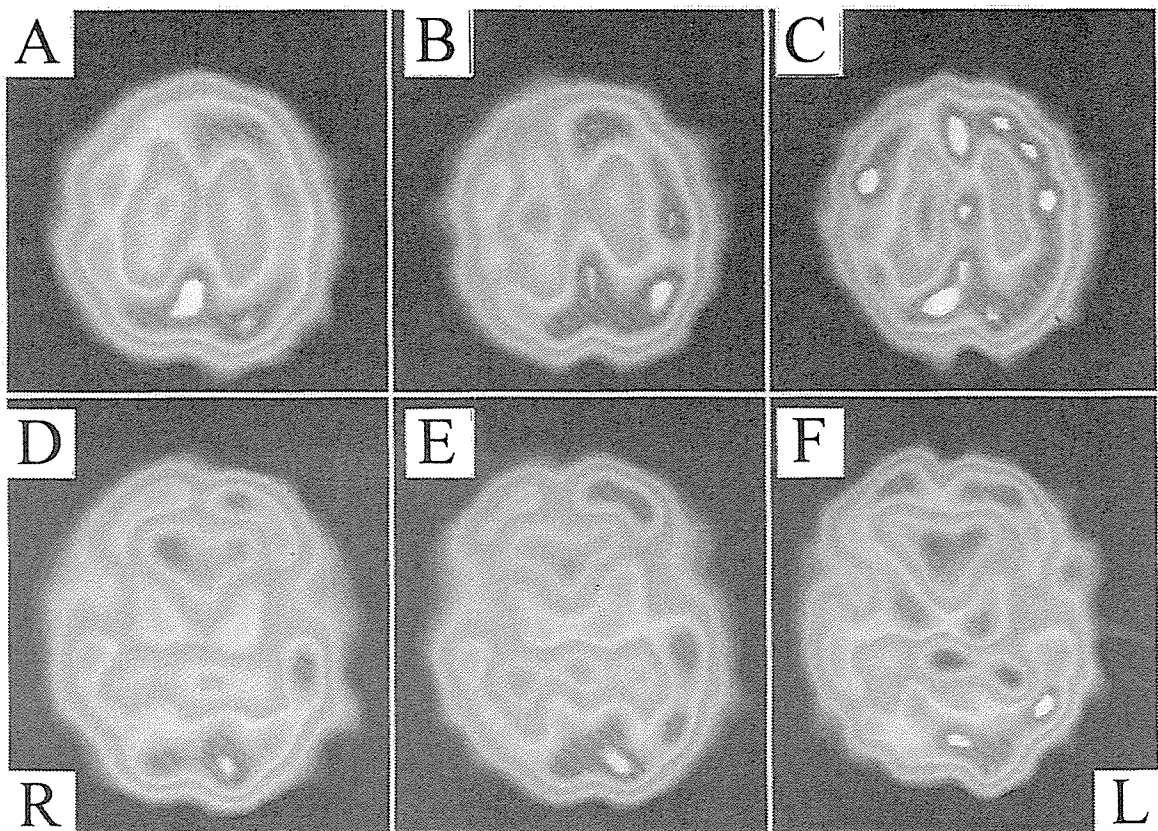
Case 1. A and D: Preoperative ¹²³I-IMP SPECT scans demonstrating severe hypoperfusion in the right hemisphere including the basal ganglia. B and E: Preoperative ¹²³I-IMP SPECT scans obtained after acetazolamide infusion, showing a marked decrease in the vascular reserve in the right hemisphere including the basal ganglia. C and F: Postoperative ¹²³I-IMP SPECT scans demonstrating improvement in the CBF in the right hemisphere including the basal ganglia.
